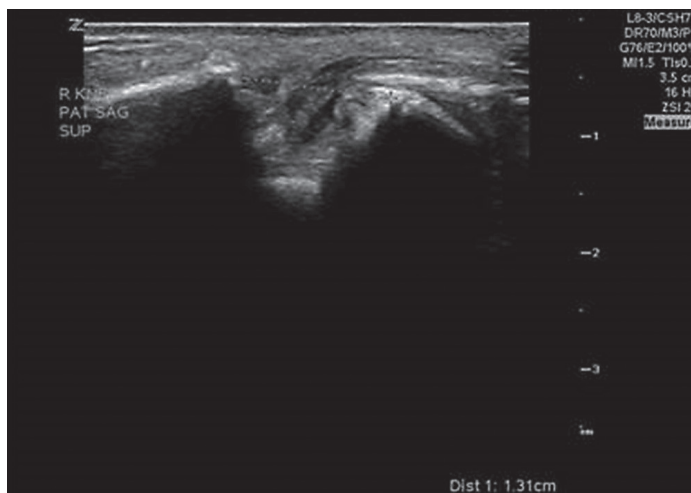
Ultrasonographic image of the right patella using a linear L8-3 probe (Zonare Z One Pro Ultrasound System) in the sagittal plane overlying the patella demonstrates a 1.31 cm patellar cortex disruption superior-inferiorly.
